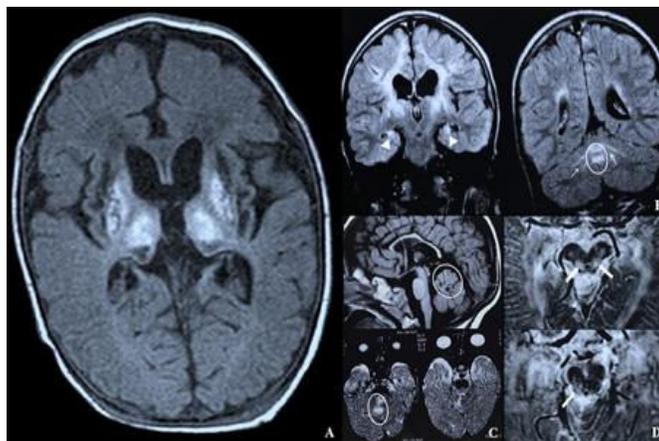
Examples of brain MRI in newborns with the most severe HIE. In the case of very severe HIE (Patient No. 4), the thalami and basal ganglia are heavily affected, often symmetrically (Panel A, axial T1 SE MRI). Abnormal signals confirm the extent of the cerebral injury and indicate involvement of the cerebellar vermis and anterior cerebellar hemispheric white matter. They also indicate probable damage to the deep dentate nuclei (small thin arrows and empty circle) and bilateral injury to the hippocampi (white arrowheads) (Panel B, FLAIR MRI). Panel C shows the abnormal vermian signal (C, axial T2 SE MRI, empty circle) and initial atrophy of the superior-anterior third of the vermis (upper half of Panel C, sagittal T1 MRI, empty circle). Panel D clearly demonstrates bilateral involvement of the dorsal pons and midbrain (white arrows) (axial T2 SE MRI).
